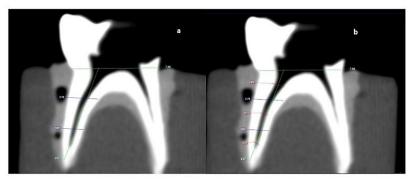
(a) Coronal CBCT image showing the "reference line" connecting the CEJ mesiodistally and the "Total Root Length" connecting the previous line to the root apex (b): Dividing each of coronal, middle, and apical root thirds into halves.
